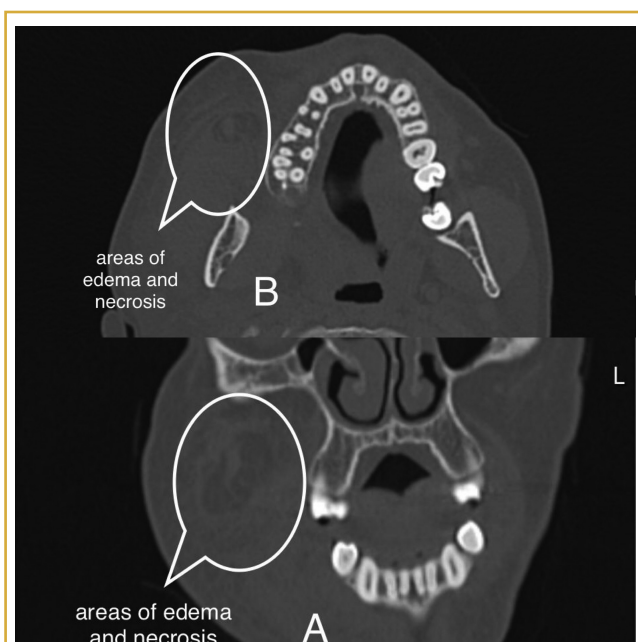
(A) Computed tomographic image of the patient in the coronal plane. (B) Computerized tomographic image of the patient in the axial plane.
